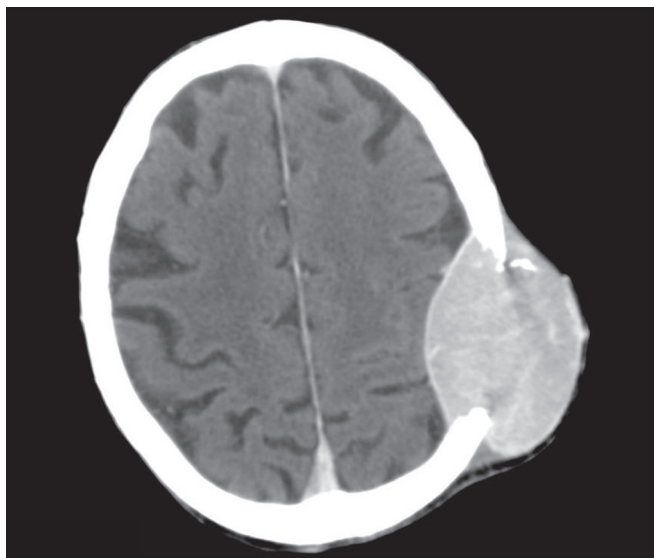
Contrast-enhanced axial multidetector computed tomography (MDCT) shows an hypervascular skull metastases. Courtesy of Dr. Massimo Galia, Dipartimento di Biotechnologie Mediche e Medicina Legale, Section of Radiological Sciences, University of Palermo, Palermo, Italy.
